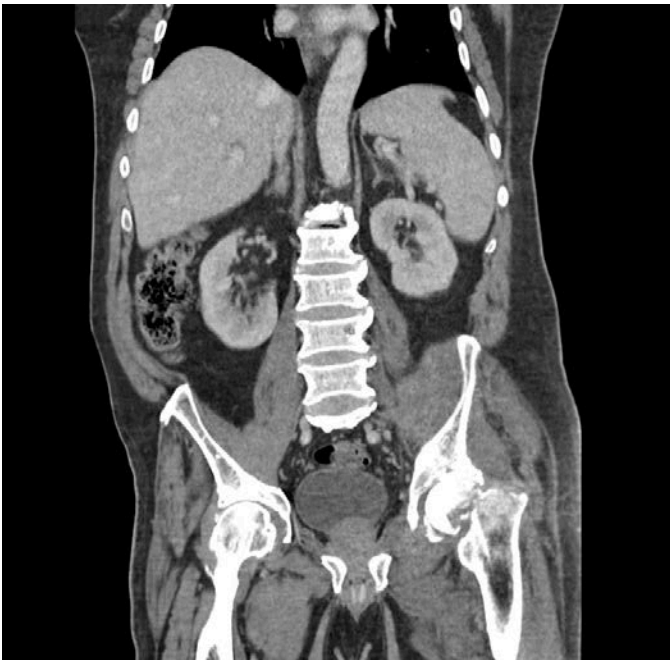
Coronal view of CT abdomen on re-presentation, revealing recurrence of abscess as well as left femoral hip fracture.
